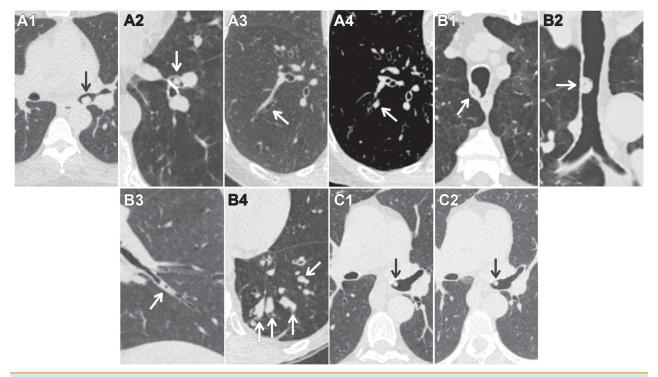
Airway nodules. (A) Airway nodules in Lung CT Screening Reporting and Data System (Lung-RADS) v2022 are characterized by location, morphology, number, and persistence. New segmental or more proximal airway nodules with a lack of benign features are classified as Lung-RADS 4A with a recommendation of 3-month low-dose CT (LDCT) to assess for resolution (A1: left main stem nodule [arrow], A2: left lower lobe segmental bronchus nodule [arrow]). Subsegmental airway nodules are classified as Lung-RADS 2 (A3: baseline lung cancer screening [LCS] with patent subsegmental airway [arrow], A4: annual LCS CT with new subsegmental airway nodule [arrow]). (B) The presence of air within an airway nodule, specifically in the absence of a soft tissue component, with mean attenuation < 21 Hounsfield units favors secretions (B1, B2, B3 [arrows]). Multiple tubular airway opacities favor mucous plugging (B4, arrows). These findings may be classified as Lung-RADS 2. (C) A 70-year-old patient with a left main stem bronchus soft tissue nodule at annual LCS (C1, arrow) is classified as Lung-RADS 4A and is stable at 3-month LDCT (C2, arrow). Airway nodules that persist at follow-up remain suspicious and are upgraded to Lung-RADS 4B with a recommendation for diagnostic evaluation, typically referral for clinical evaluation and bronchoscopy.
